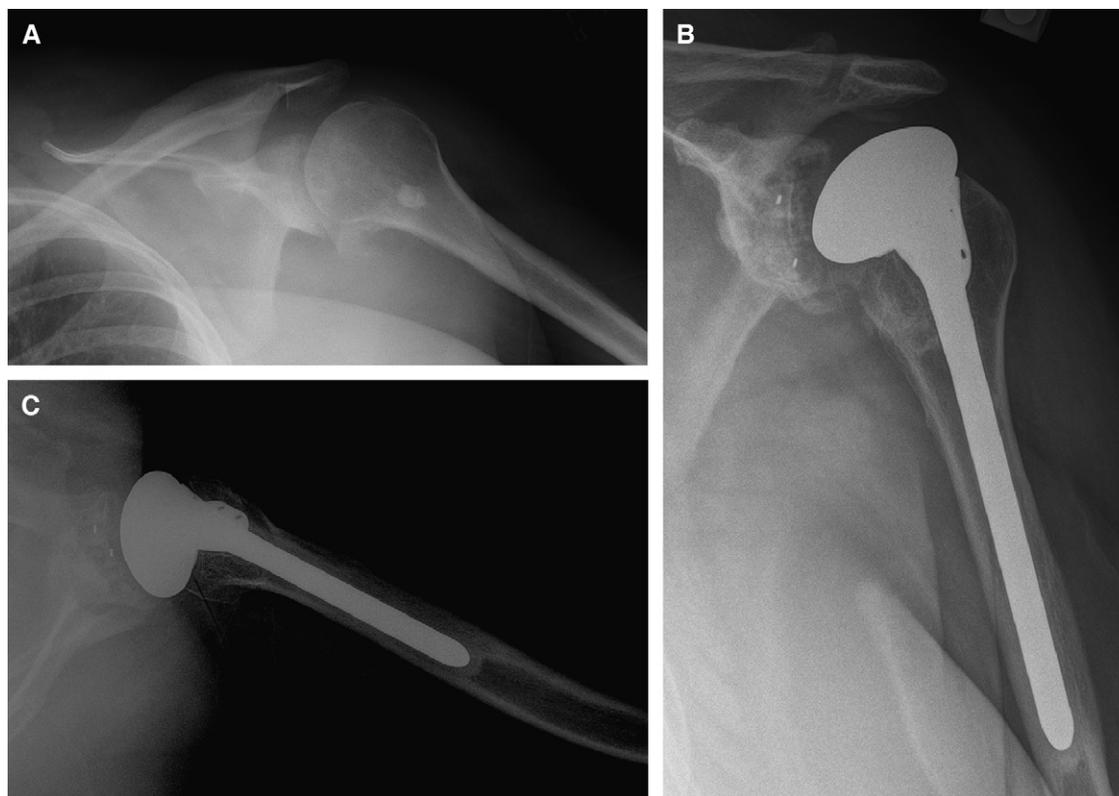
(A), Preoperative radiograph of a 49-year-old woman before total shoulder arthroplasty. She had severe pain, active elevation to 100° , and passive external rotation of 30° . (B) and (C), Radiographs taken 5.5 years after surgery. The patient reported moderate pain and showed 100° of active elevation and 40° of external rotation. Periprosthetic glenoid lucency and central migration are noted.
